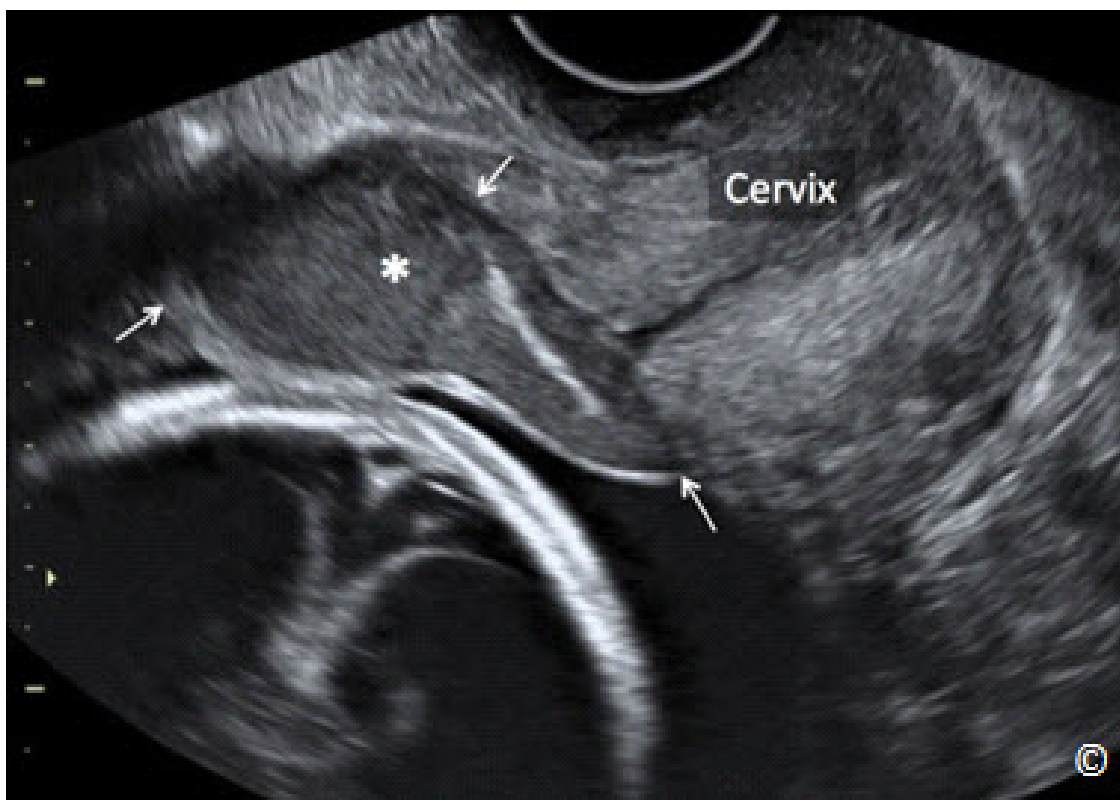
Transvaginal ultrasound of a pregnancy with a placental abruption. Note the presence of a blood clot (asterisk and arrows) behind the membranes and in front of cervix (labeled). Note that ultrasound can miss a placental abruption on many occasions – see text for details.
